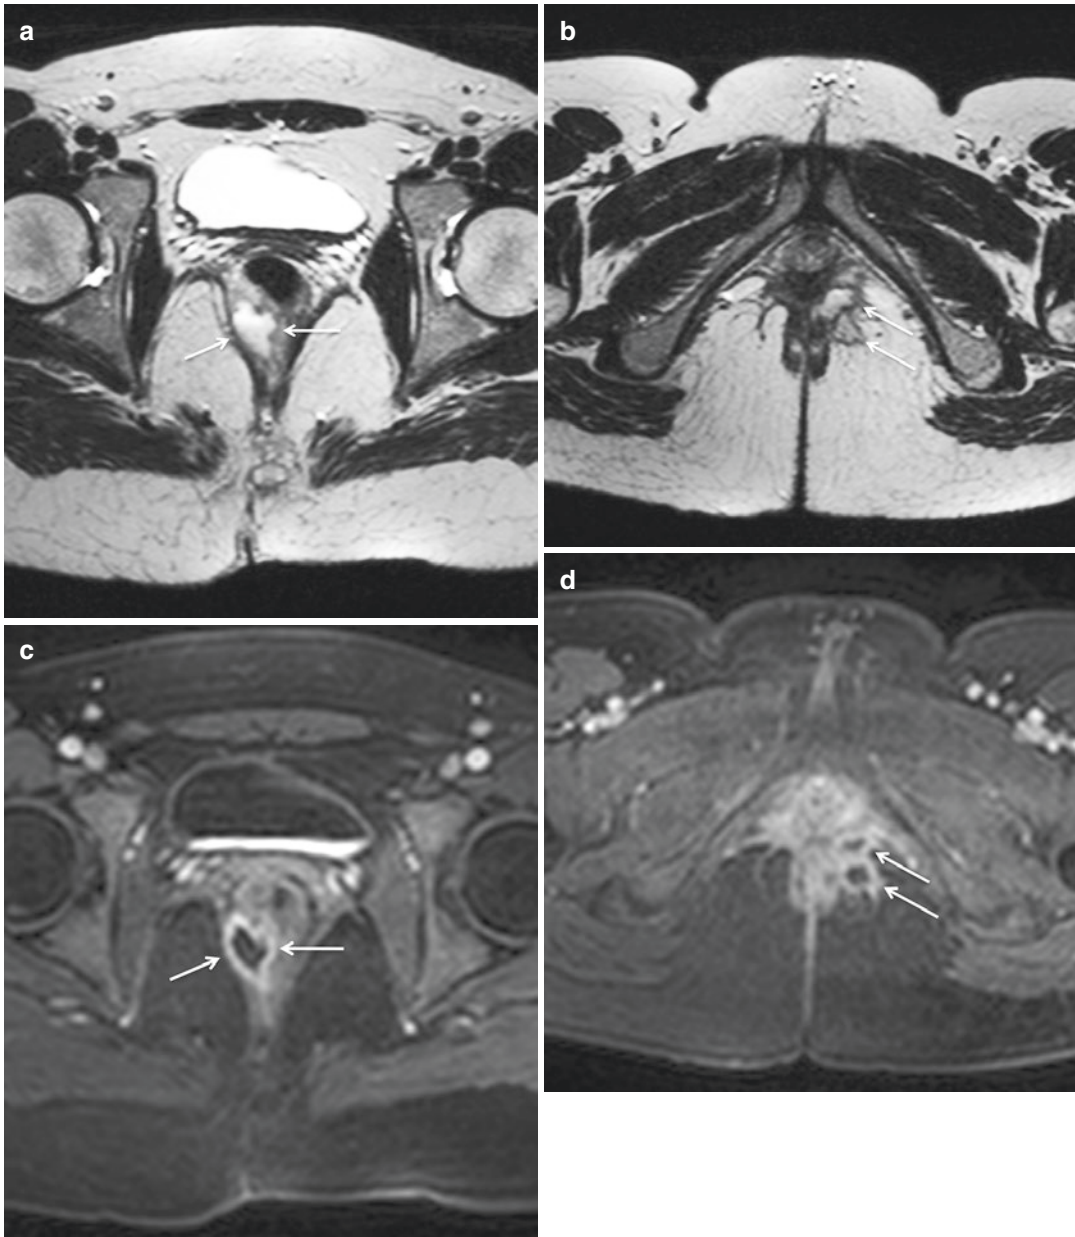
Perianal fistula with multiple abscesses. Axial-oblique T2-weighted TSE image (a) shows a right-sided abscess (arrows). A more caudal scan (b) demonstrates other two small abscesses in the left ischioanal fossa (arrows). Axial-oblique T1-weighted TSE fat-saturated
